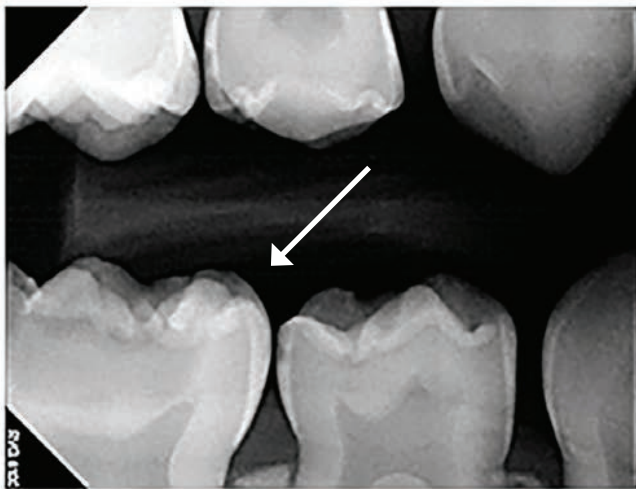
Periapical radiograph of primary right second molar prior to restoration
